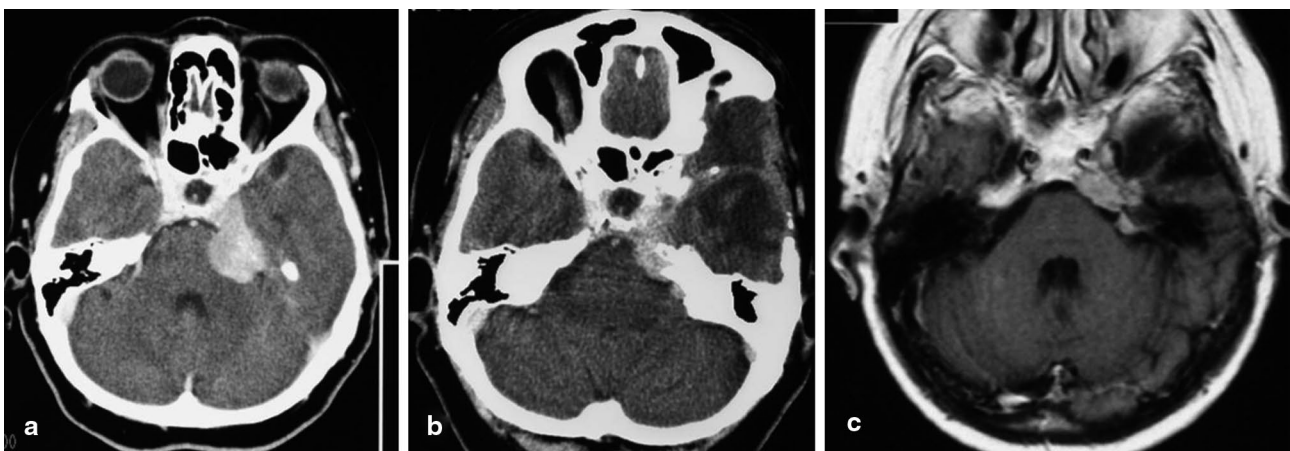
A preoperative computed tomography (CT) of a 4-cm parasellar and retrosellar petroclival meningioma (a). The control CT image showing a relapse of the petroclival meningioma, which was operatively removed 3 years earlier (b). The
